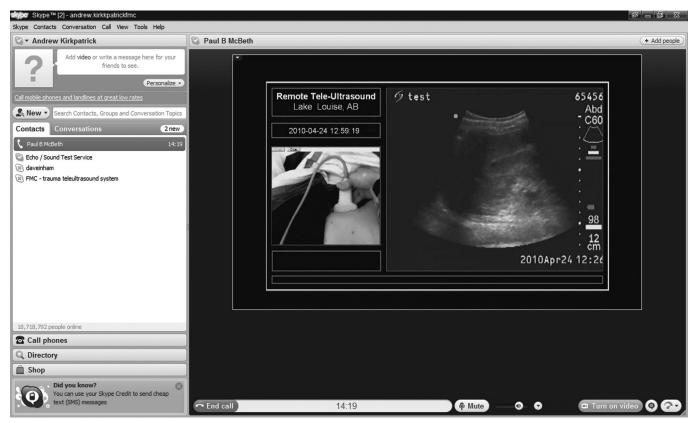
Screen shot from remote Calgary viewers laptop display. The scene image is captured on the left video window demonstrating the examiner holding the probe on the patient's right flank, whereas the right displayed the real-time streaming ultrasound video, in this instance the remote viewer is guiding the POC provider to optimize the splenorenal interface.
